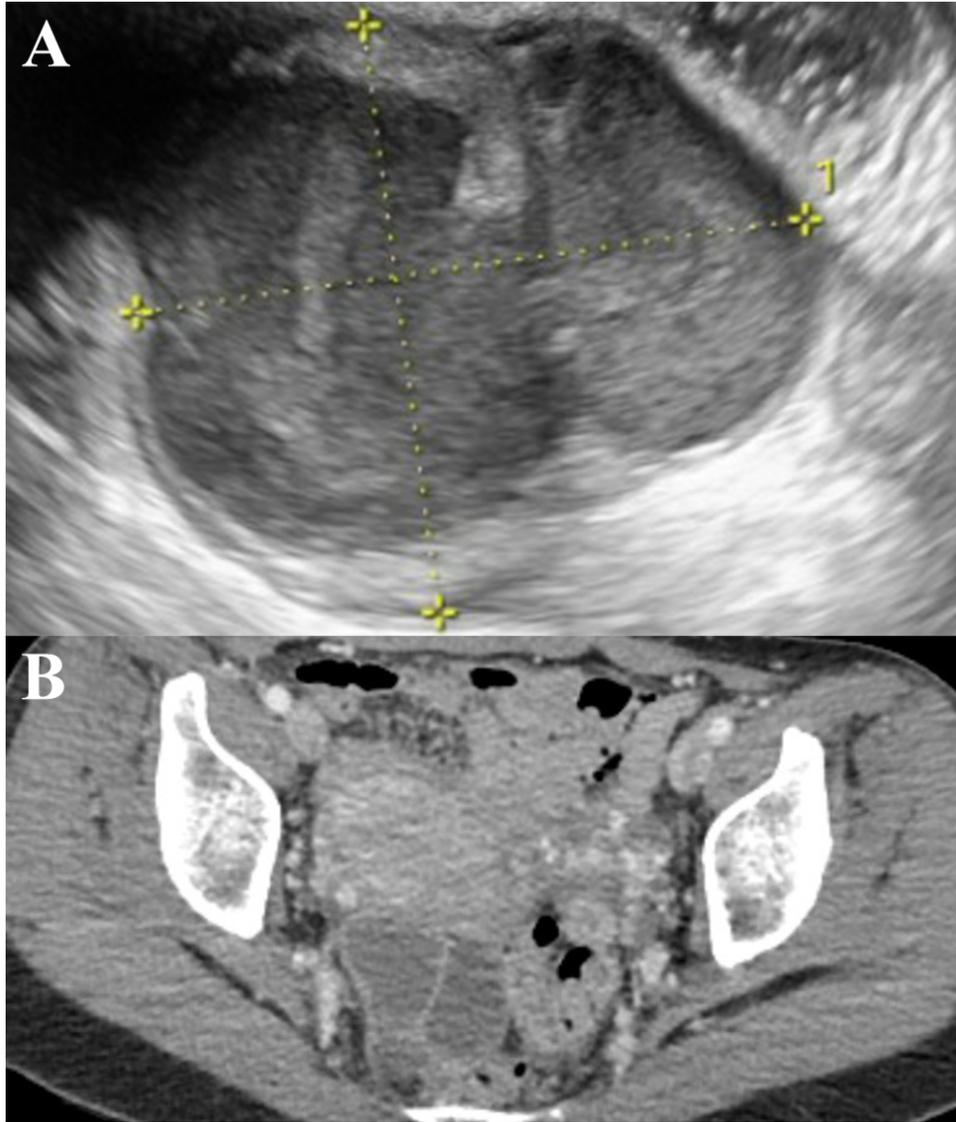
Imaging of the right ovarian cystic mass. A. Transvaginal ultrasound image of the 3.8×3.3 cm right ovarian cystic mass. The tumor was homogeneous, composed of low-level echoes, and the cyst wall was regular and smooth. B. Abdominal and pelvic computed tomography of the 3.5 cm right ovarian cystic mass showed that the tumor was a low-attenuation, thin-walled, unilocular cyst without solid components.
